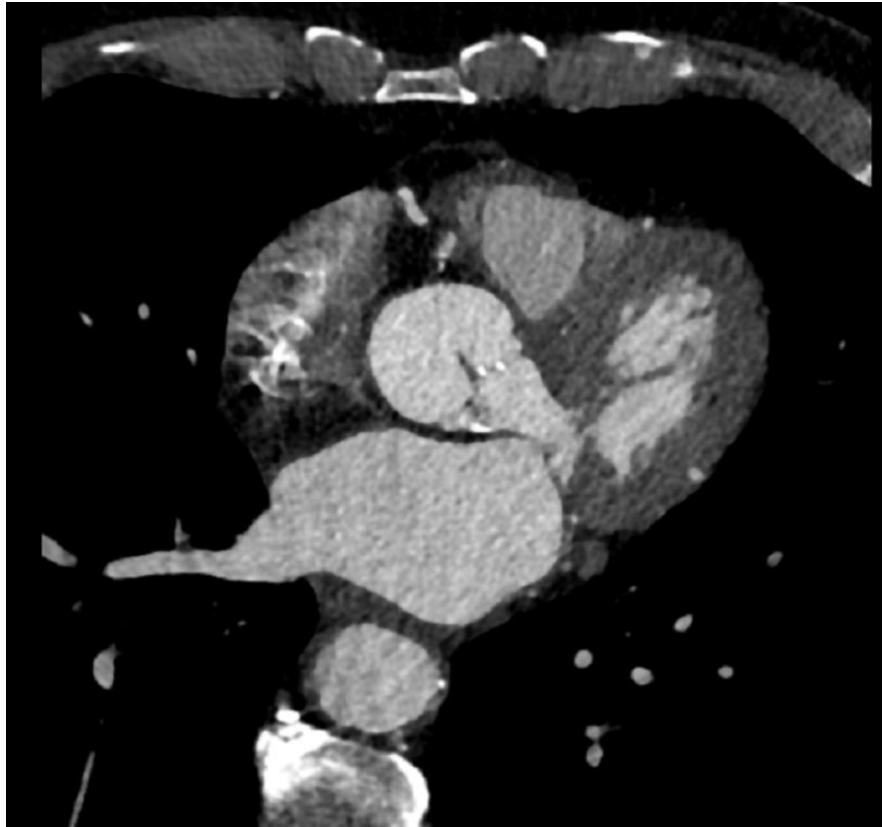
Typical CT scan depicting at the center of it the LA cavity with the right superior PV and the other chambers.
